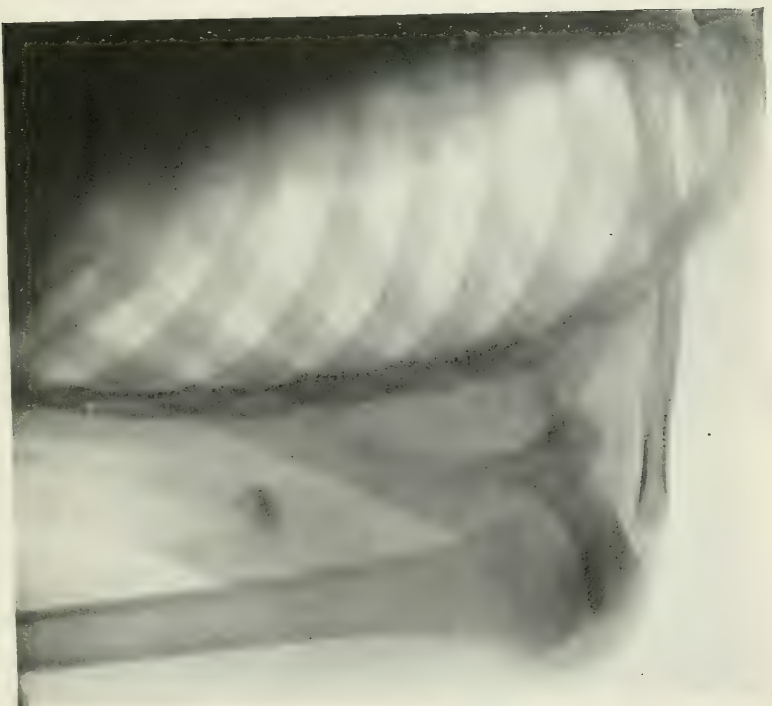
Radiograph showing condition of shoulder after capsulorrhaphy.
